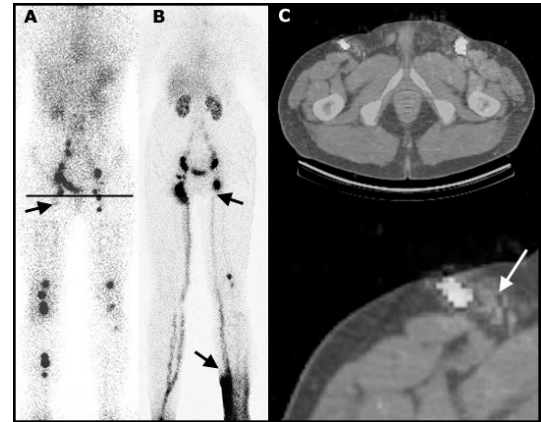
RNL staging. Stage L_{2A} : Slow lymphatic transport within the superficial and visualization of the deep lymphatic system as a compensatory route (A,B). Distal lymph stasis and no blockade. Visualization of superficial non-functional inguinal lymph nodes at the SPET-CT fusion image (white arrow), but normal deep system with functional popliteal and retrocrural nodes.
